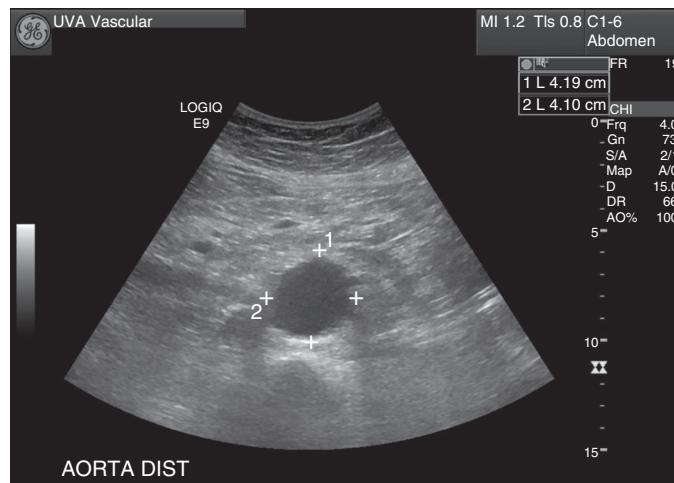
Ultrasound of the abdominal aorta documents an abdominal aortic aneurysm noted with maximal measurement of 4.19 × 4.10 cm in the anteroposterior and transverse dimensions.
